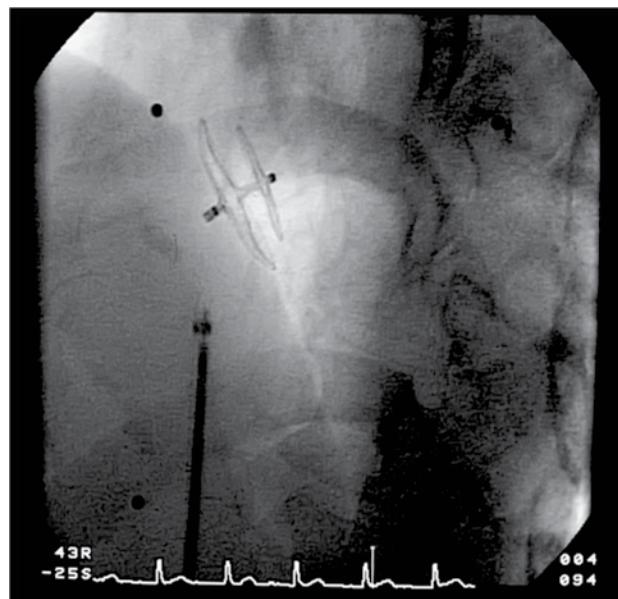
Final release of the Amplatzer occluder under transesophageal echocardiographic and angiographic control. © St. Jude Medical, 2014. Reproduced with permission.
